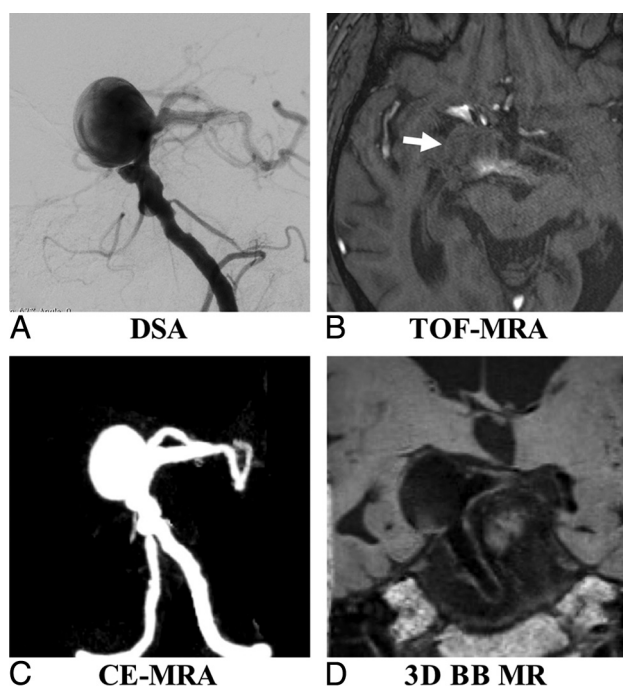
A 53-year-old man with multiple basilar artery aneurysms on DSA (A). The aneurysm shows isointensity on TOF-MRA (B) because of the slow flow (arrow). The aneurysm sac and neck were integrally visualized on CE-MRA (C) and 3D-BB MR imaging (D).
